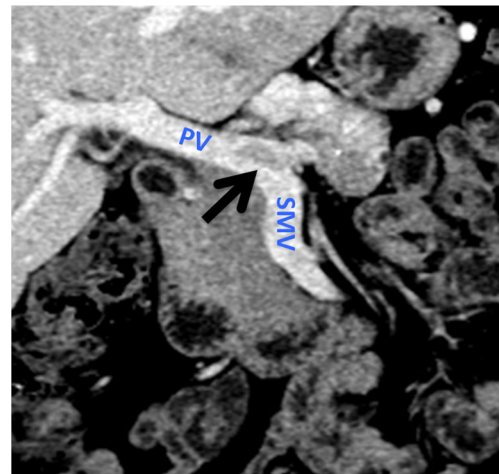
Preoperative CT image from a 38-year-old woman following the administration of neoadjuvant chemotherapy. A pNET in the pancreatic body extends posteriorly along the splenic vein into the confluence of the portal vein (*PV*) and superior mesenteric vein (*SMV*)
